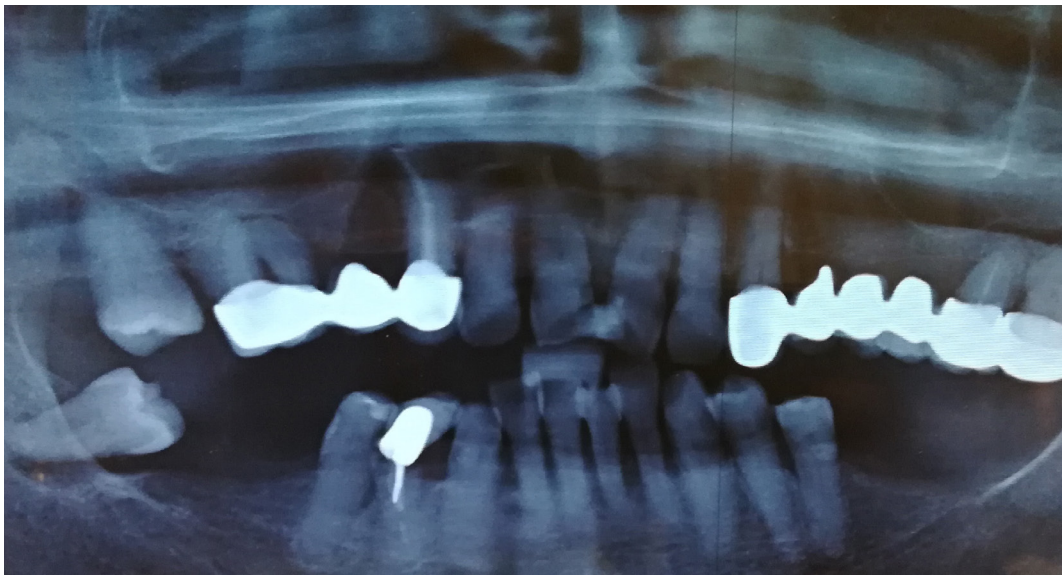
Initial orthopantomography.*
